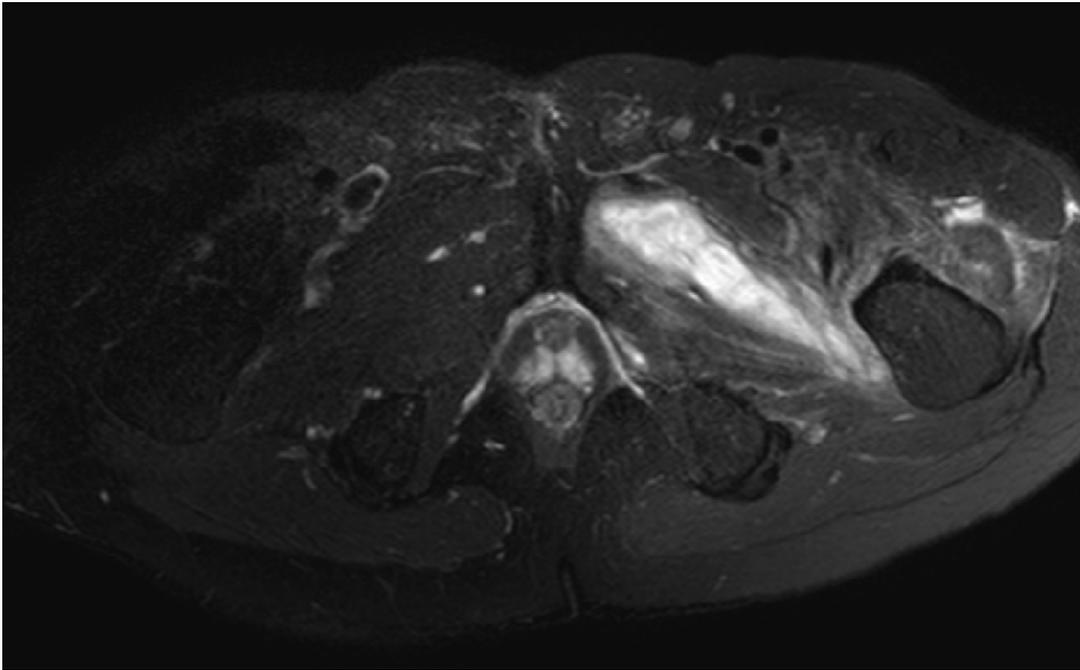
Magnetic resonance imaging of the adductor muscle abscess of pneumococcal pyomyositis in case 2.
